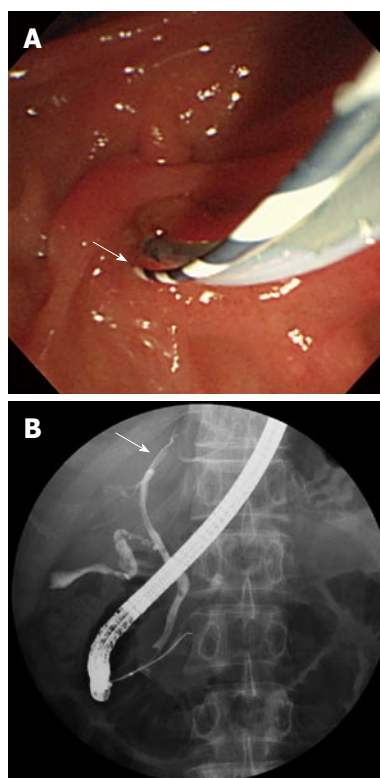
A guidewire in the bile duct and catheter. Because the papilla was very mobile, a guidewire was retained in the bile duct and the catheter is pressed to the duodenal papilla while the pancreatic duct direction is probed with the guidewire inserted into the catheter. Arrows indicate bile duct guidewire-indwelling. A: Endoscopic image of duodenal papilla; B: X-ray image.
